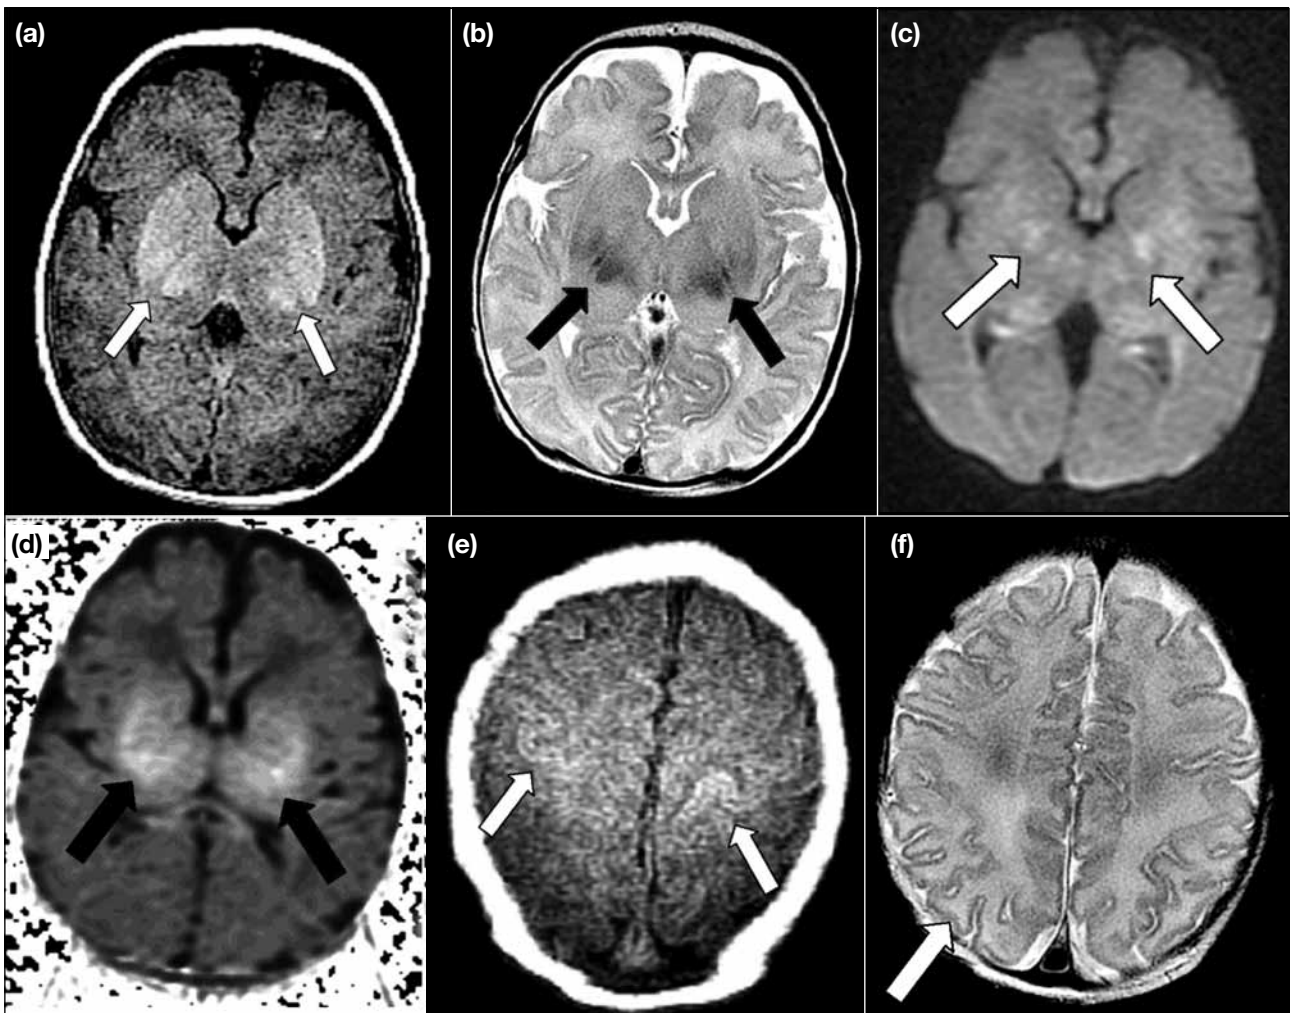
Magnetic resonance imaging of patient 8 with severe hypoxic ischaemic encephalopathy showing (a) T1-hyperintense and (b) T2-hypointense bilateral deep grey matter including bilateral thalami, putamina, and globus pallidi (arrows), restricted diffusion at the bilateral posterior limb of the internal capsule on (c) diffusion-weighted image and (d) apparent diffusion coefficient image (arrows), (e) mild signal abnormality at central and interhemispheric fissures on T1-weighted image (arrows), and (f) mild signal abnormality of diffuse white matter with increased T2-weighted signal at the bilateral frontoparietal regions (arrow).
